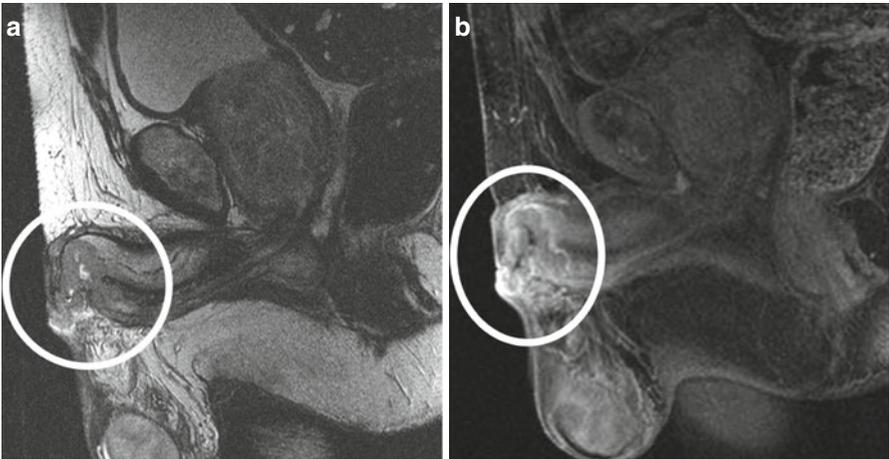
(a, b) Sagittal T2 MRI image (a) demonstrating a squamous cell carcinoma of the glans penis extending into the urethra indicative of T3 disease. Note the high-signal or “bright” urine within the bladder (T2 image) and BPH. Sagittal T1 MRI image post-IV contrast (b) demonstrating the T3 glans tumour. The administration of IV contrast (gadolinium) increases the contrast between normal adjacent tissue and abnormal enhancing “bright” tumour
